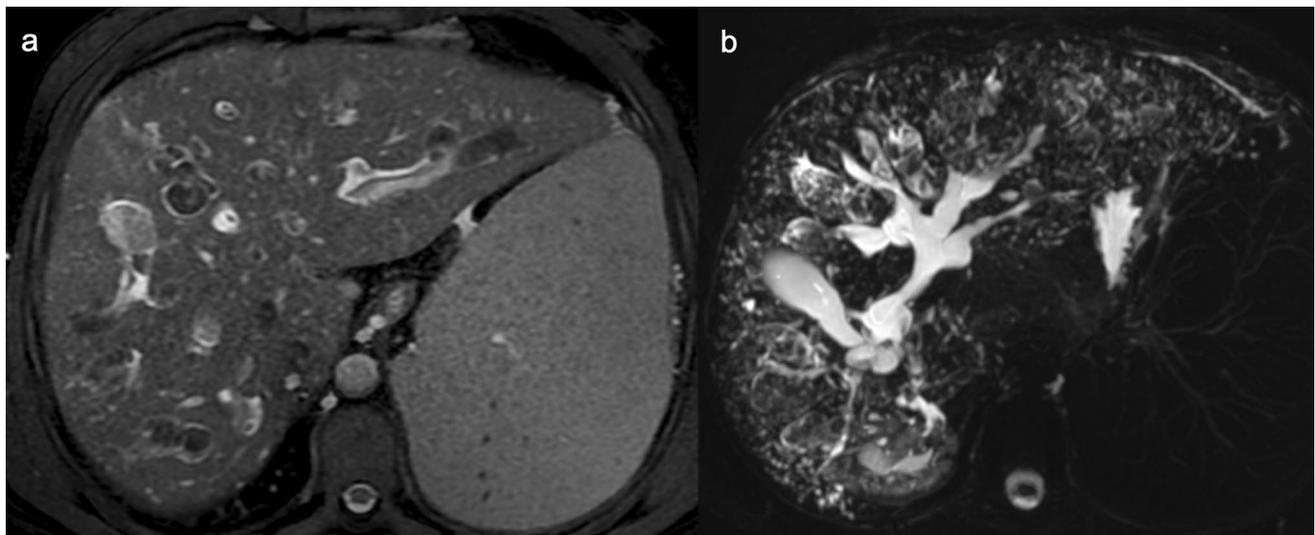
von Meyenburg Complex. Axial T2-w (a) and 3D MRCP Maximum Intensity Projection reconstruction (b) MRI images in a patient with coexistence of biliary hamartomas (multiple tiny T2
